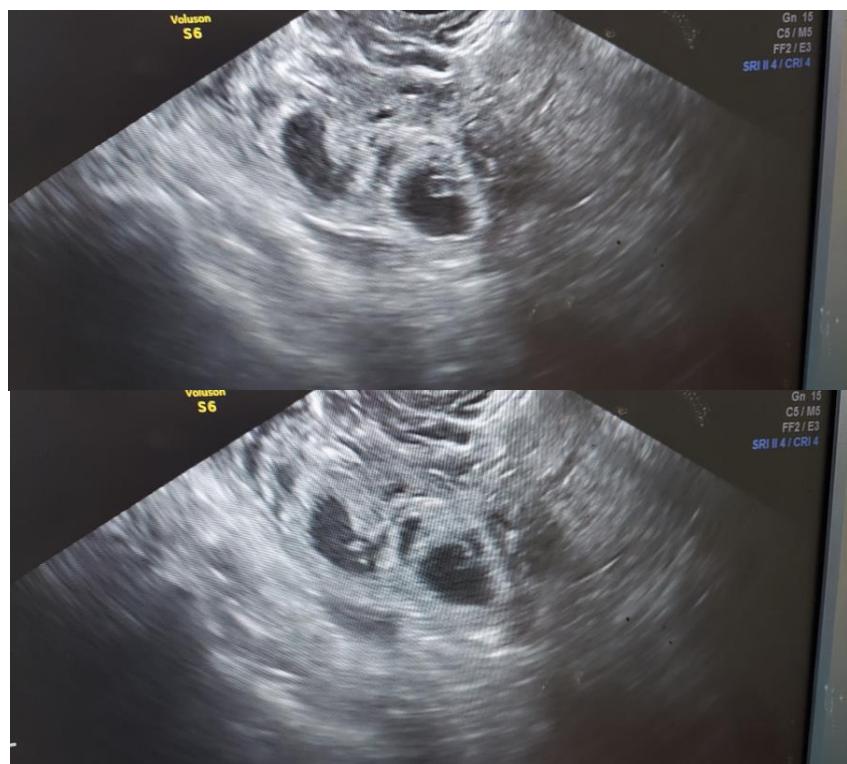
Transvaginal ultrasound (sagittal view) showing an empty uterine cavity and a right adnexal mass containing two distinct gestational sacs (arrows)
